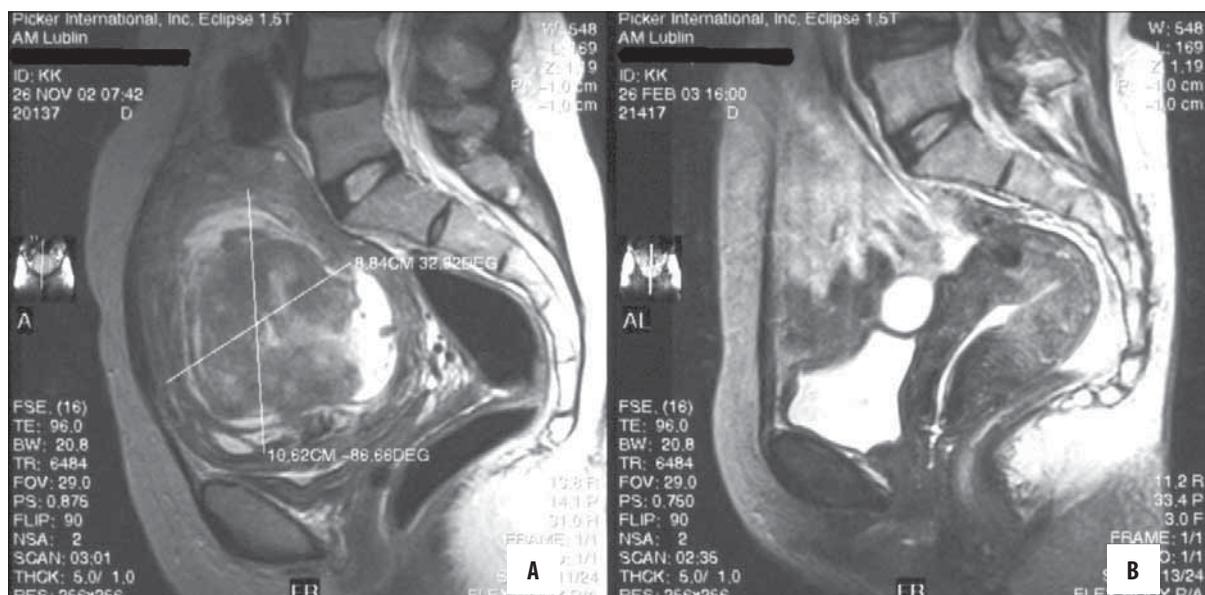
MRI T2-weighted sagittal images before UFE (A) and 3 months later (B). (A) large submucosal fibroid causes urinary bladder compression, abnormal bleeding and anemia (B) uterus after transvaginal expulsion.
